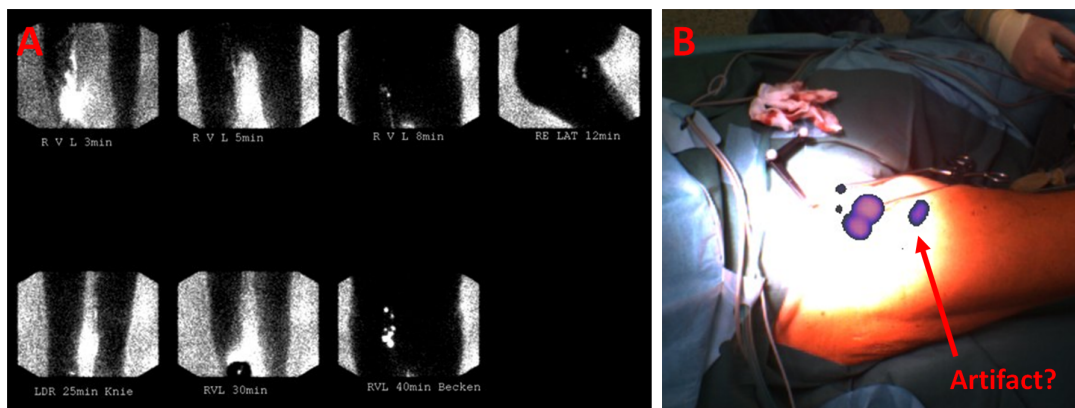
Example of groin case. In (A) planar scintigraphy shows a complex drain to the groin with several nodes. Freehand SPECT image reconstructs correctly the lower SLNs, however a spot appears in direction caudal which is not seen in scintigraphy. Confirmation with gamma probe shows that the spot is an error of sampling.
